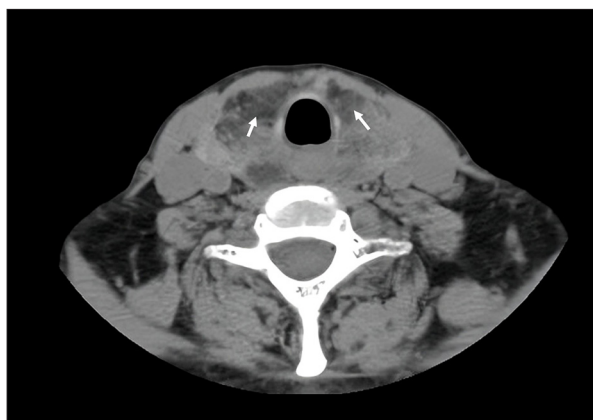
Computed tomography of the neck without contrast. CT scan showing diffuse goiter with hypodense areas (white arrows).
